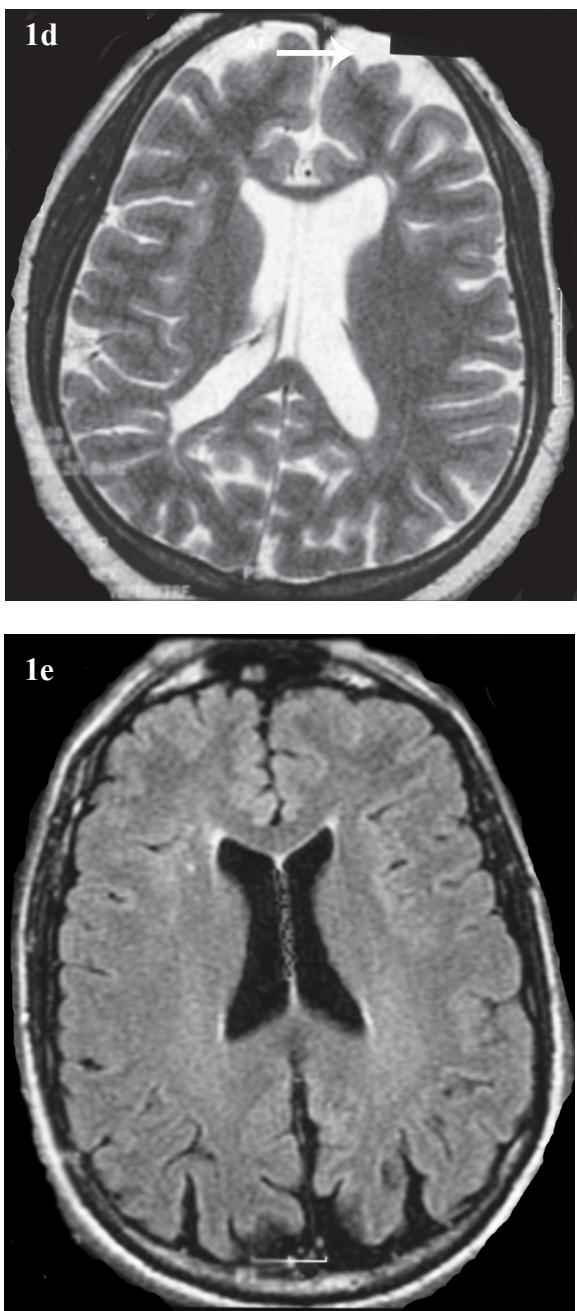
MRI images (with annotating arrows) demonstrating low signal on T2-weighted axial imaging representing iron deposition in the basal ganglia (1a) and dentate nucleus of the cerebellum (1b). Sagittal T1-weighted image demonstrates anterior callosal thinning (1c), likely secondary to frontal cortical atrophy as seen on a T2-weighted axial slice (1d). Fluid-attenuation inversion recovery (FLAIR) axial slice shows periventricular "cupping" (1e).
